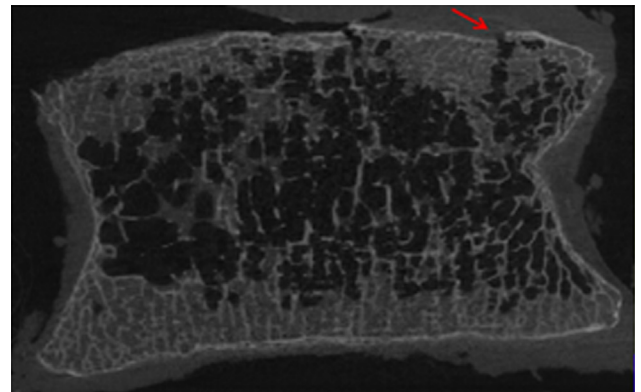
CT slice of a L1 vertebra. Fracture of the endplate (shown by red arrow) at the control level.
